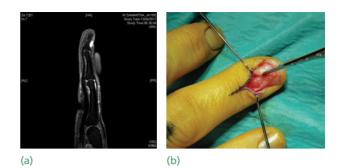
Glomus tumour (a) MRI showing tumour beneath the nail; (b) removal under local anaesthetic.
